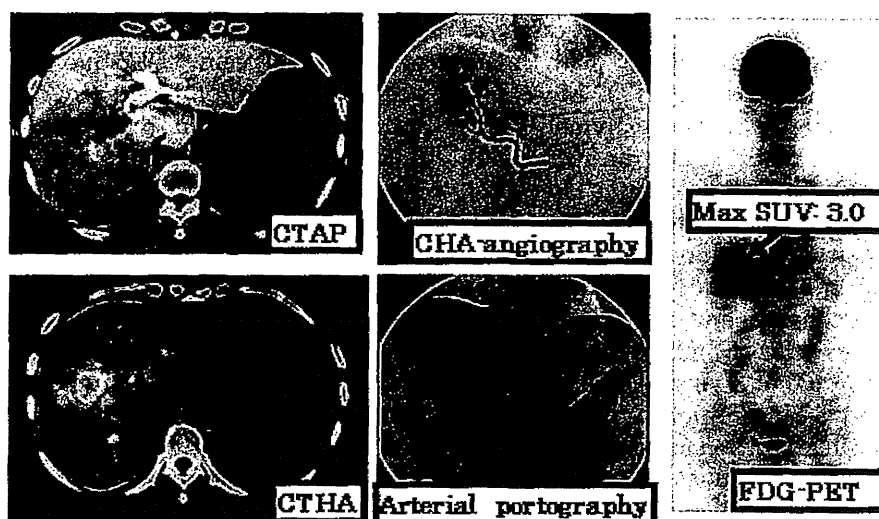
CT arterial portography and CT hepatic arteriography reveal a tumor, in the right lobe of the liver, that infiltrated the main trunk via the first branch of the portal vein. Arterial portography using contrast medium reveals a flow defect at the main trunk of the portal vein. FDG-PET reveals abnormal uptake in the right lobe of the liver (maximum standardized uptake value, 3.0).
